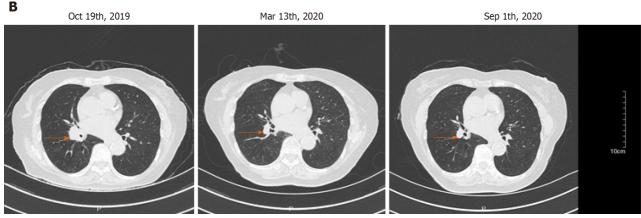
Course of treatment of patients with diabetes induced by immune checkpoint inhibitors. A: Changes of gastrin-releasing peptide precursor level during each period; B: Contrast-enhanced chest computed tomography during each period. Red arrows indicate the tumors.
